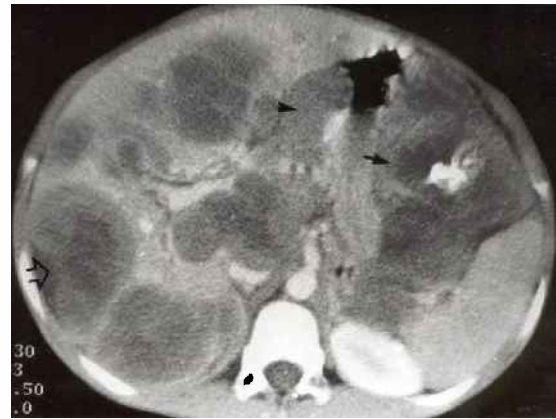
Contrast-enhanced CT image of the abdomen shows a heterogeneously-enhancing mass lesion (arrow) with internal calcification. The mass is located in the greater omentum. There are coeliac and gastrohepatic lymphadenopathy (arrowhead) and multiple hypodense lesions in the liver.
